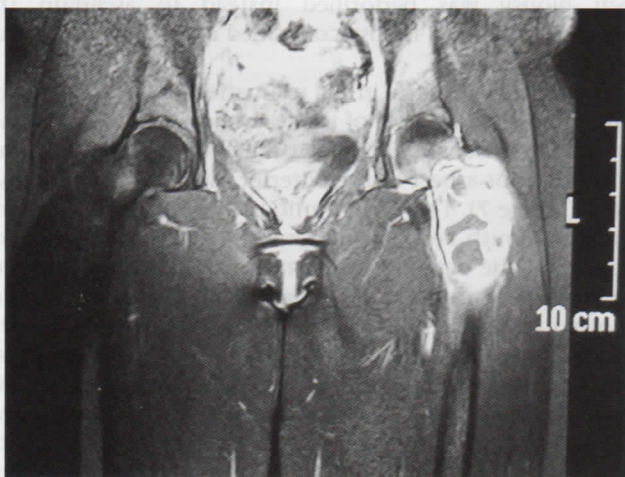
On MRI, the primary lesion appears to be multilobulated with bright signal on a T2-weighted image that is bordered by a thin rim of low signal.
